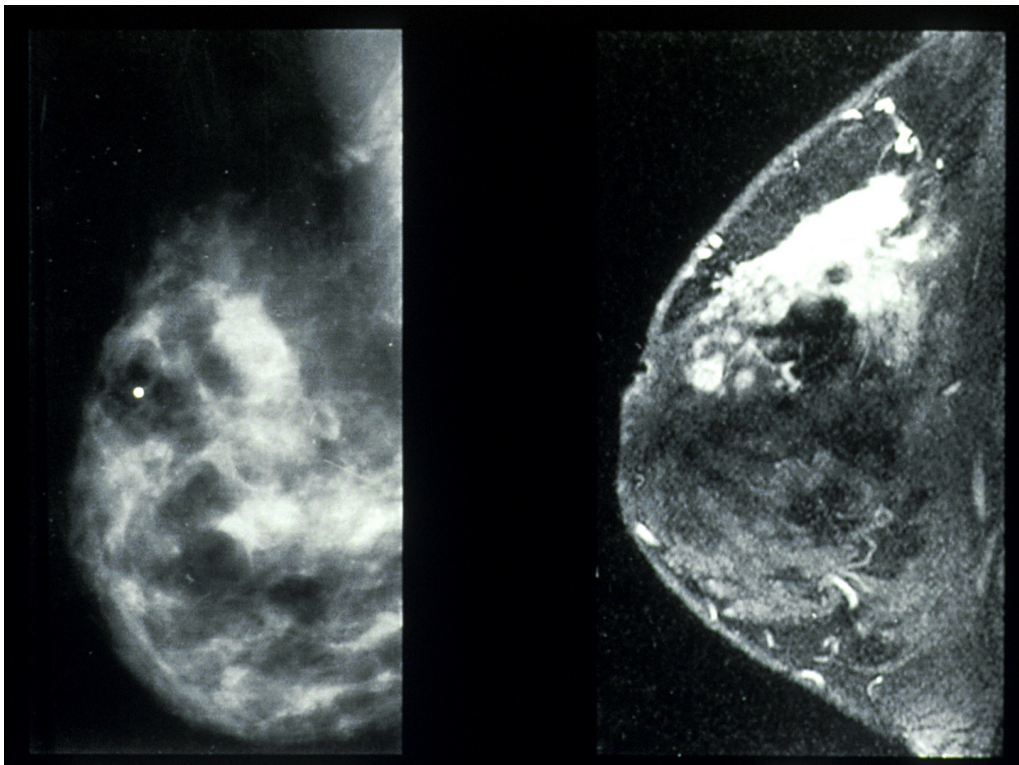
Mammography (left) and MRI (right). MRI enhanced image was used to confirm diagnosis of a palpable cancer. The corresponding abnormality has been indicated with a white dot in the left mammogram, which failed in the detection<sup>9</sup>.*
